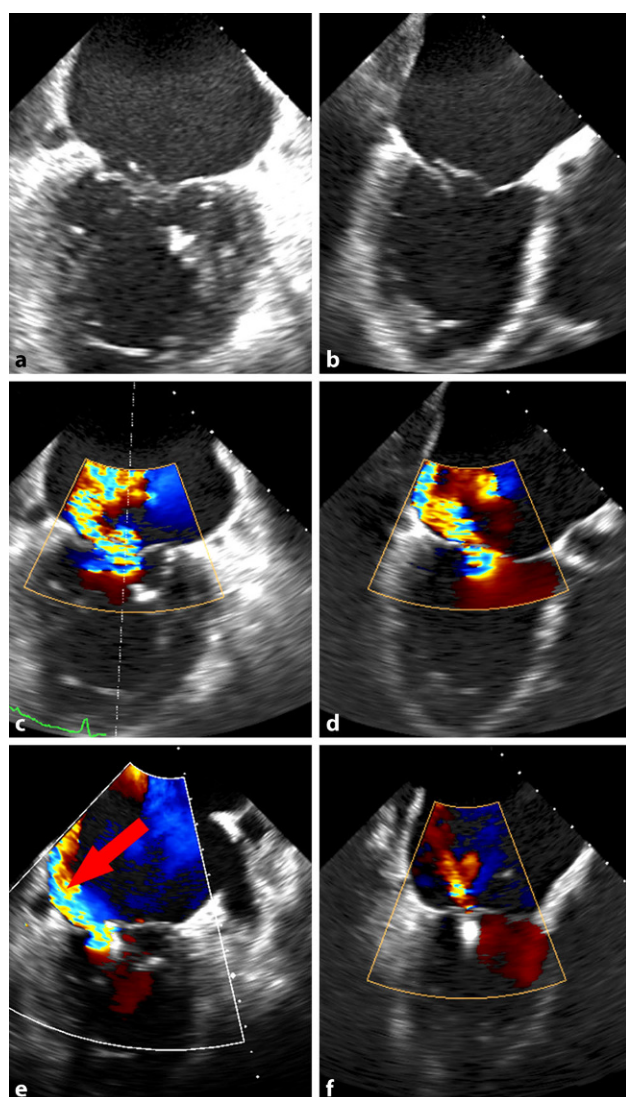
Transesophageal echocardiography in patient no. 8 with mixed mitral regurgitation, degenerative disease with a flail of the middle scallop of the anterior leaflet (A2) and annular dilatation due to long-standing atrial fibrillation, before MitraClip implantation (a intercommissural view, b long axis view, c intercommissural view with color Doppler flow, d long axis view with color Doppler flow) and immediately after MitraClip implantation with significant residual regurgitant jet medial to the clip (*arrow*; e intercommissural view with color Doppler flow, f long axis view with color Doppler flow)
